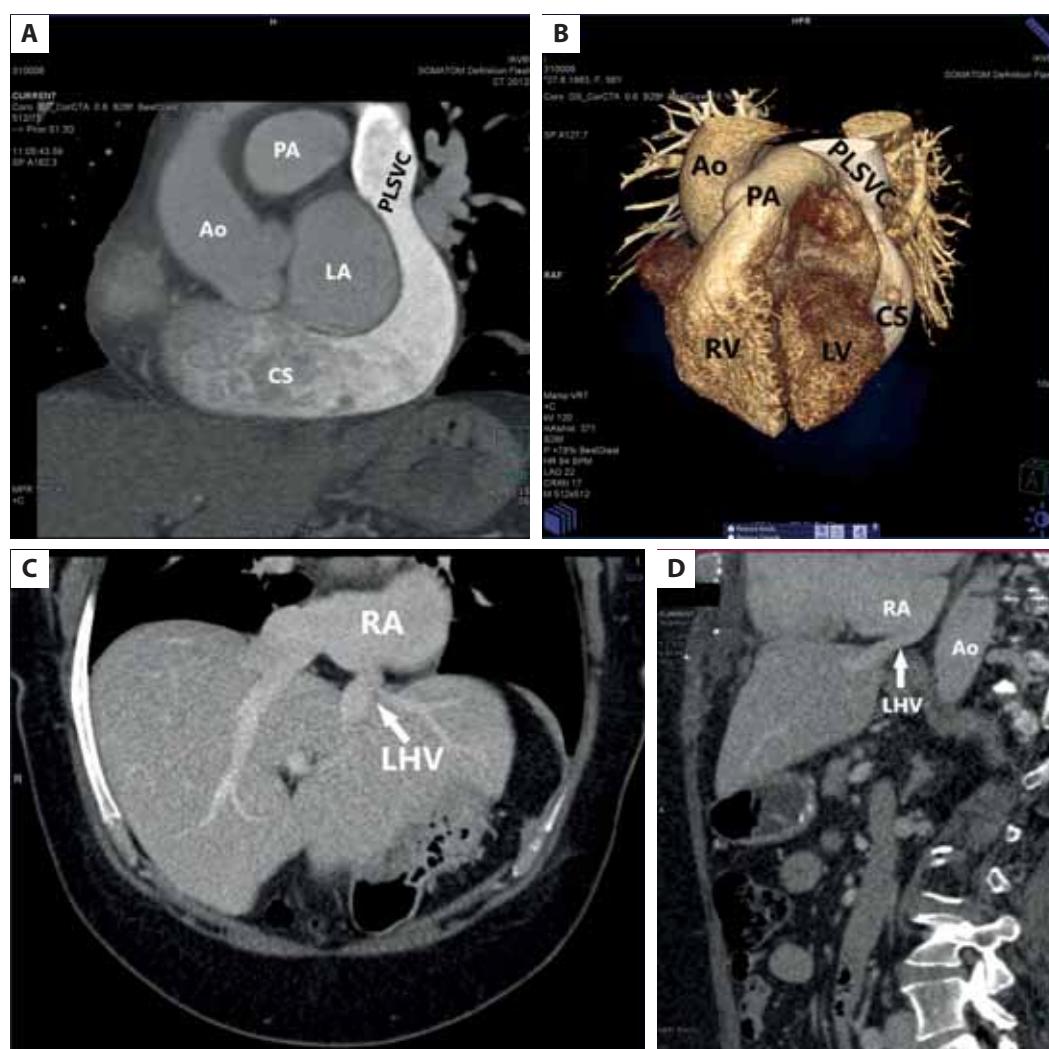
A, B. Contrast-enhanced CT of the heart: the presence of a PLSVC draining into the right atrium via the dilated CS, along with agenesis of the right superior vena cava C, D. Contrast-enhanced CT of the abdomen: anomalous LHV drainage into the RA
